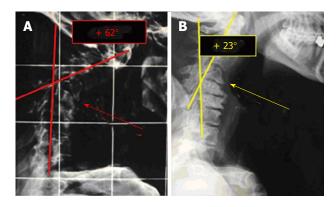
X-ray pictures. A: Standard X-ray demonstrating a severe cervical kyphosis (preop. Angle of Jackson + 62°); B: A cervical spine X-ray on the bed with a pillow under the shoulders showing a good reduction of kyphosis (+ 23° according to Jackson) due to the motor unit C4-C5 mobility.
